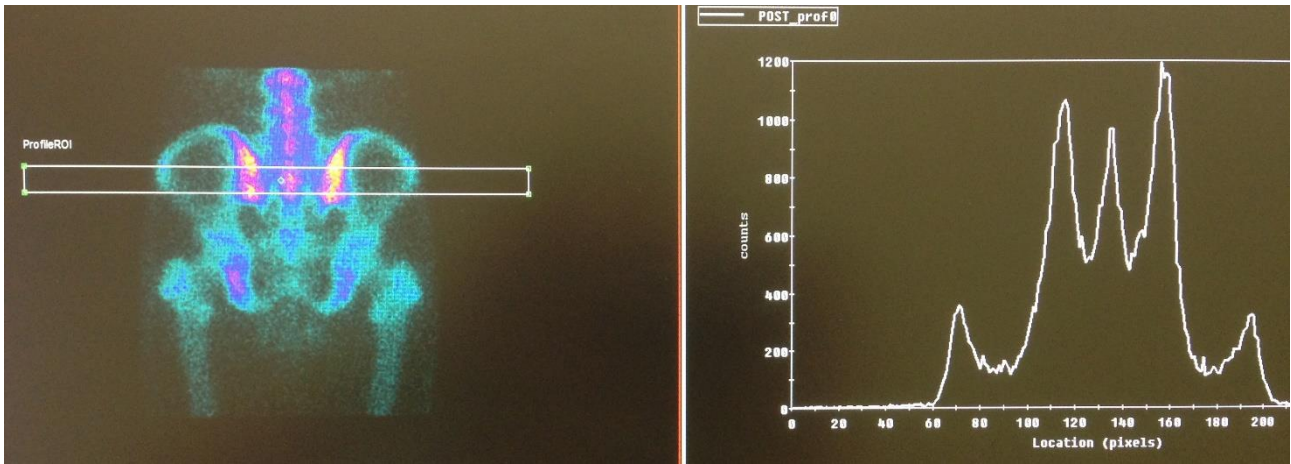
Horizontal rectangular ROI method. A horizontal rectangular ROI was placed on both sacroiliac joints and sacrum in posterior pelvis image of bone scintigraphy. Three separate peaks that shows maximum counts on the profile for both sacroiliac joints and sacrum.
